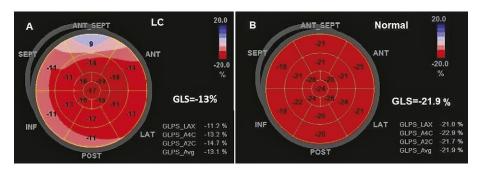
Assessment of the left ventricular myocardial deformation by speckle-trackingechocardiography. A. Bull's eye reflecting global longitudinal deformation of the left ventricle (GLS) by speckle-tracking-echocardiography in a 55 year -old liver cirrhotic men, Child C, with preserved ejection fraction and diastolic dysfunction grade 2. GLS =-13% suggests a significantly decreased longitudinal deformation (red segments, normal deformation, light red decreased strain, white no deformation at all, and blue segments dyskinesia) B. Normal GLS in a normal subject with similar age and gender.
